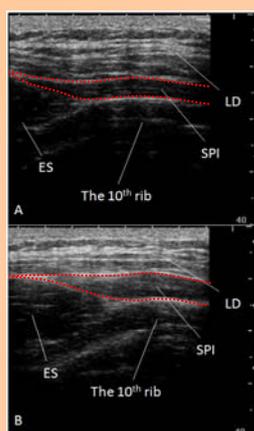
Muscle thickness of the SPI measured by ultrasonography
